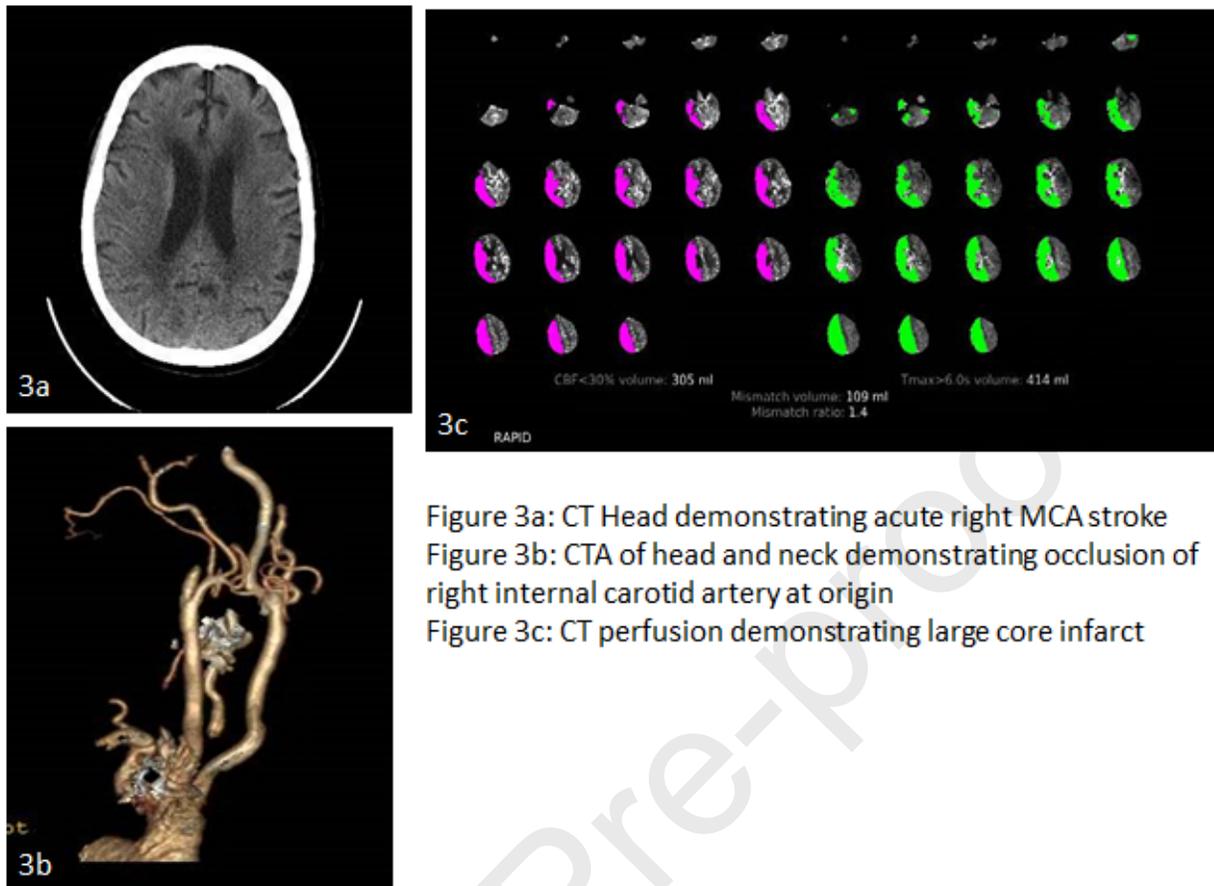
CT Head demonstrating acute right MCA stroke
